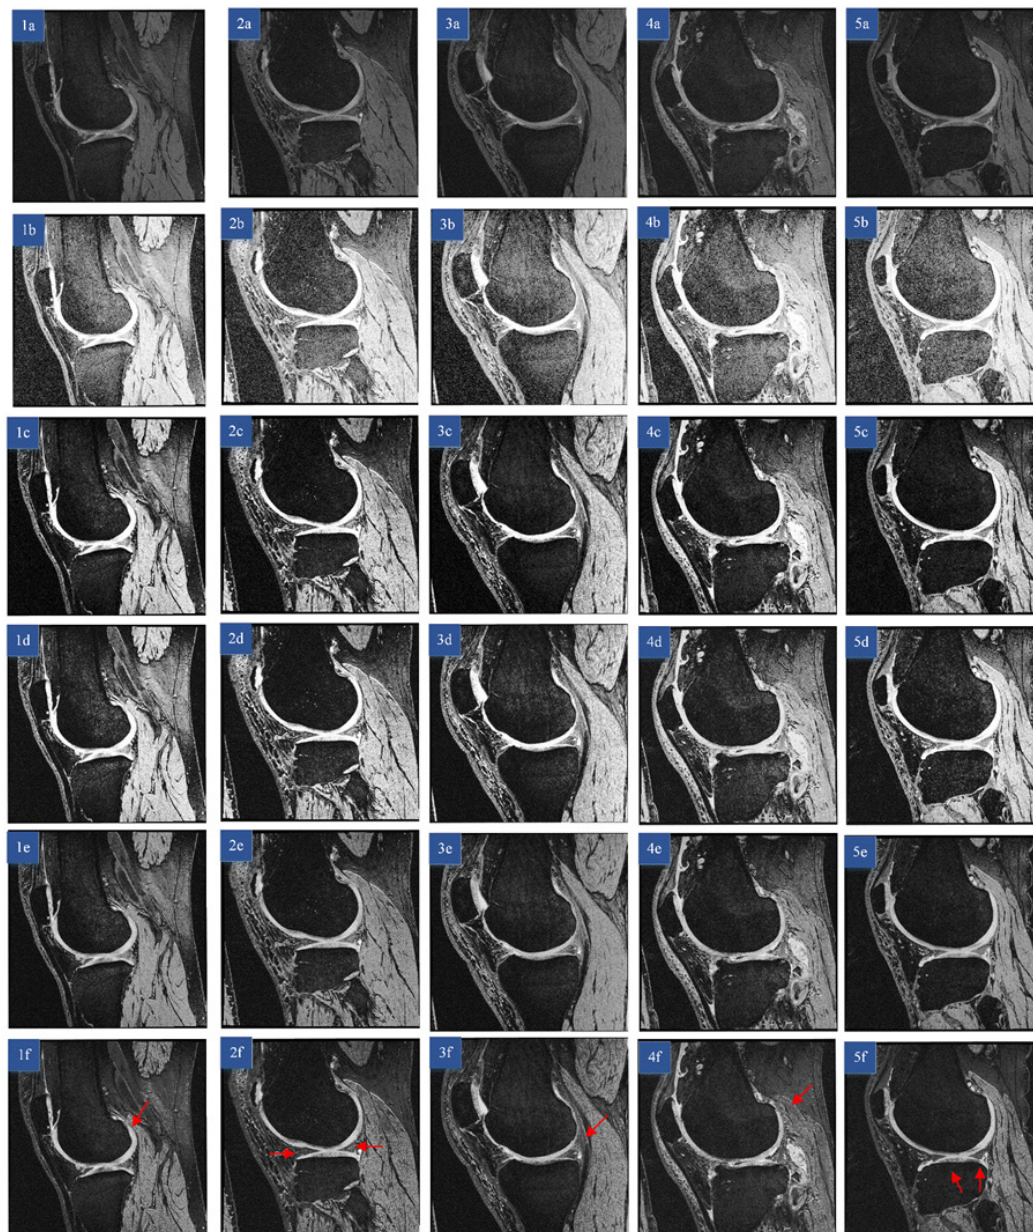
Visual result evaluation and methods comparisons. (1a-5a) Five original knee MR images are selected and enhanced with (1b-5b) HE method, (1c-5c) BBHE method, (1d-5d) DSIHE method, (1e-5e) BBCCE method and (1f-5f) PROICE method
